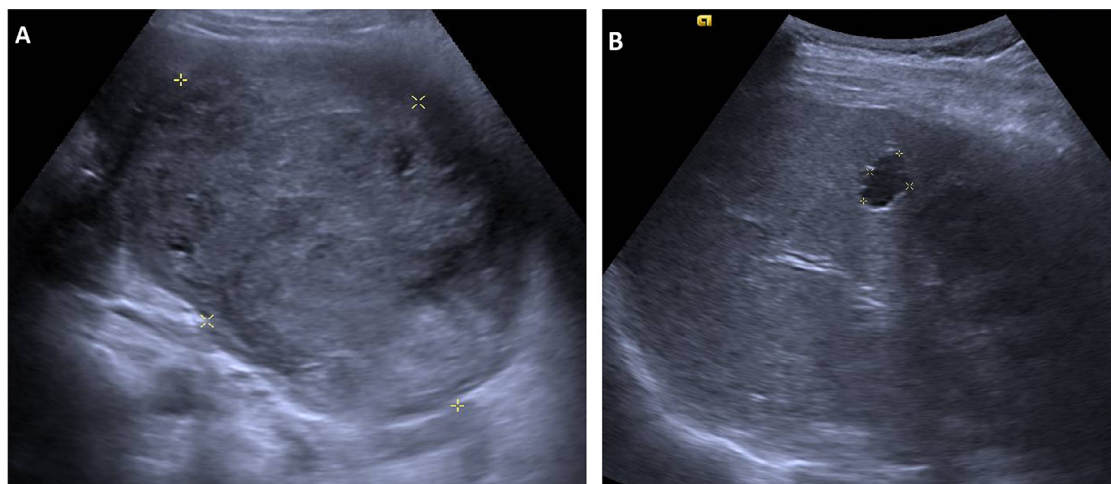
(A) Large complex cystic mass in the right lobe of the liver depicted on ultrasound, measuring 132 × 97 × 110 mm. (B) A 16-mm right lobe simple cyst also noted with surrounding coarse architecture of liver and irregular contour.
